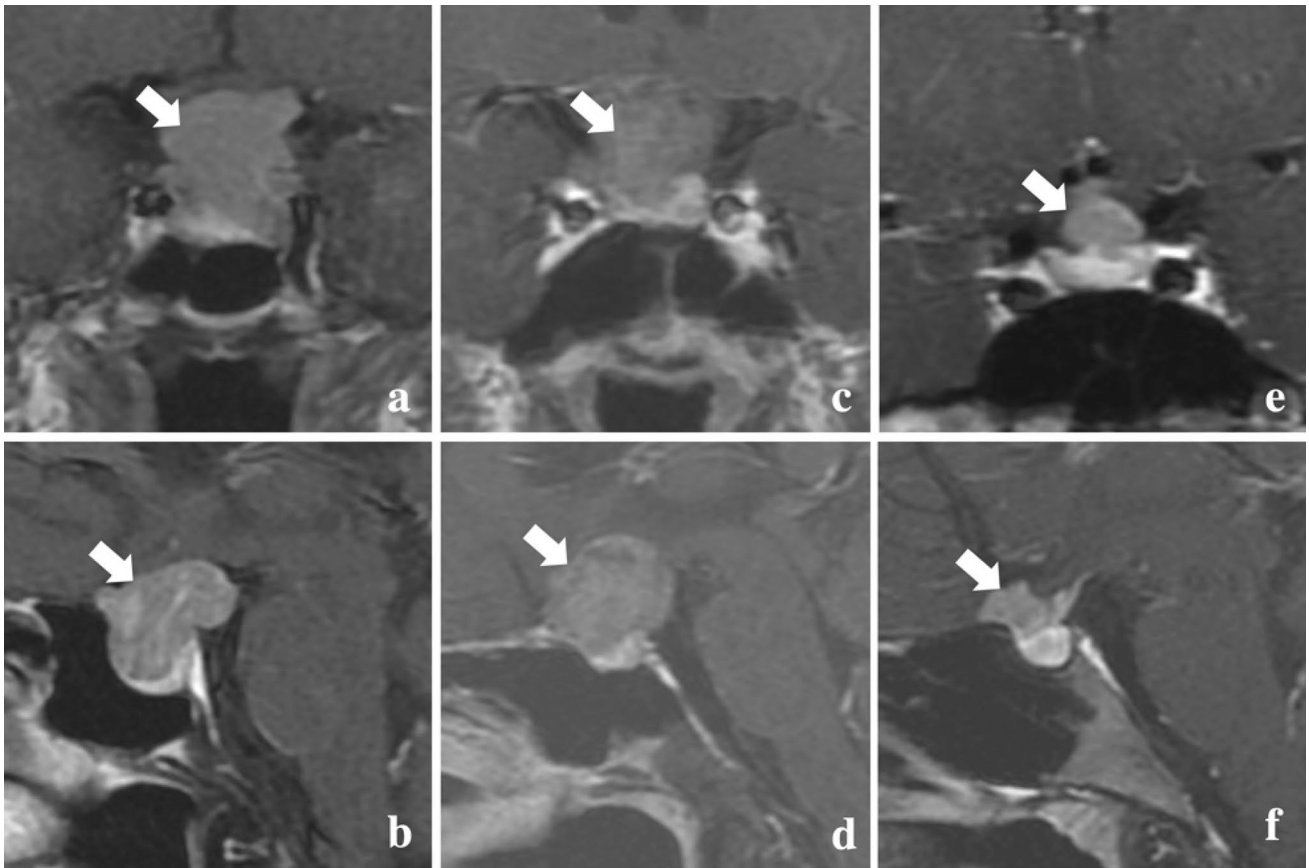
MRI presentations of Patients 1 (a, b), 2 (c, d) and 3 (e, f). White arrows show suspicious tumors
